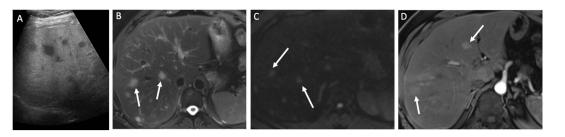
Hepatic tuberculosis. A) US of liver shows multiple hypoechoic liver lesions. MRI of the same patient reveals B) multiple T2 fat sat hyperintense liver lesions with C) associated diffusion restriction and D) post-contrast enhancement.
